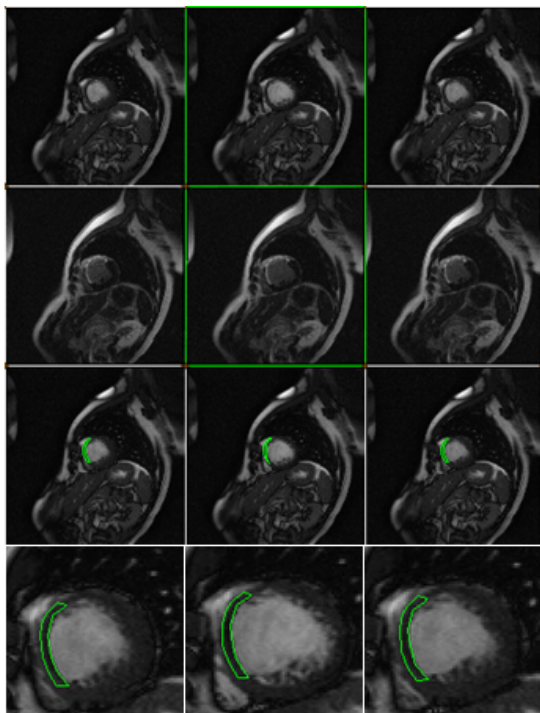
The first row is the cine images; the second row is propagated DE-MRI and the third row is propagated contour superimposed on the cine. The propagated contours are zoomed in at last row. The image with green box in the first row corresponds with C_k in Fig.1 and the image with green box in the second row corresponds with E_k^* . Due to space limit, we only present the results at three different phases.
